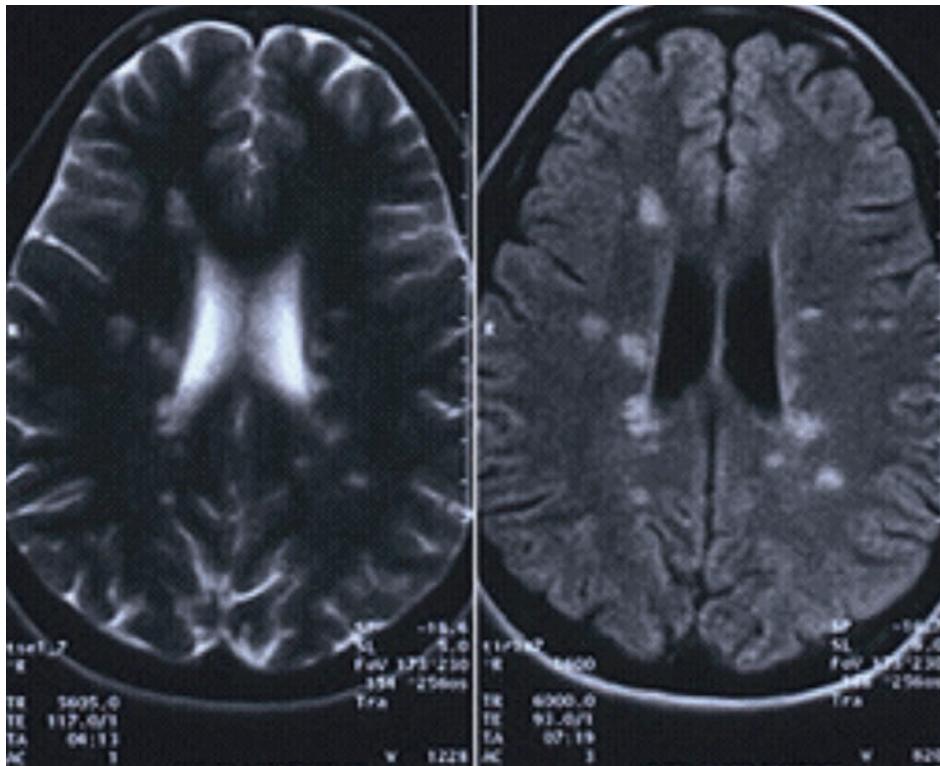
The patient's MRI reveals classic white matter lesions perpendicular to the lateral ventricles, consistent with MS. These lesions are most easily seen using the FLAIR MRI sequence. T1-weighted imaging may also help identify any active lesions.
